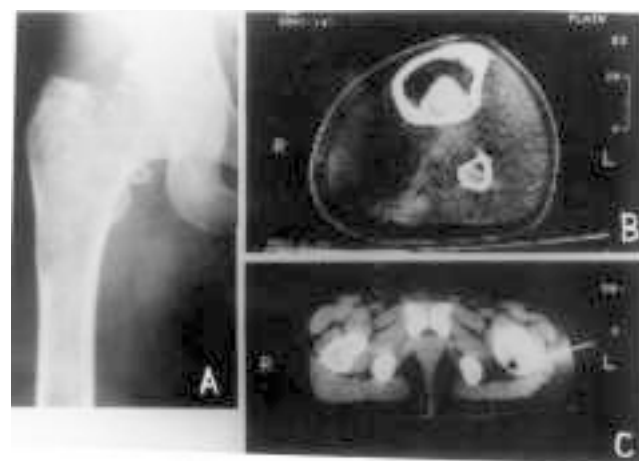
(a) Fracture neck of femur with rarefaction of proximal femur (Left), (b) CT scan showing lesions in left tibia and fibula and (c) CT guided biopsy of the neck of femur.
